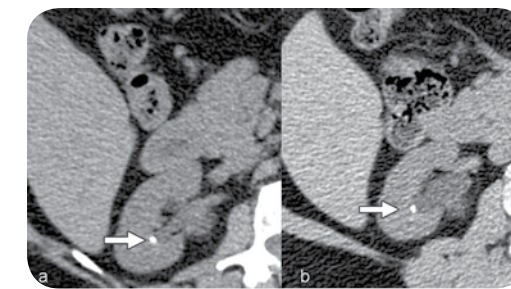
CT scans taken with normal (120kVp, 240mAs) (a) and with low-dose (100kVp, 100mAs) (b) settings, both allow confident diagnosis of the renal stone (arrow) in spite of graininess in the low dose image.
